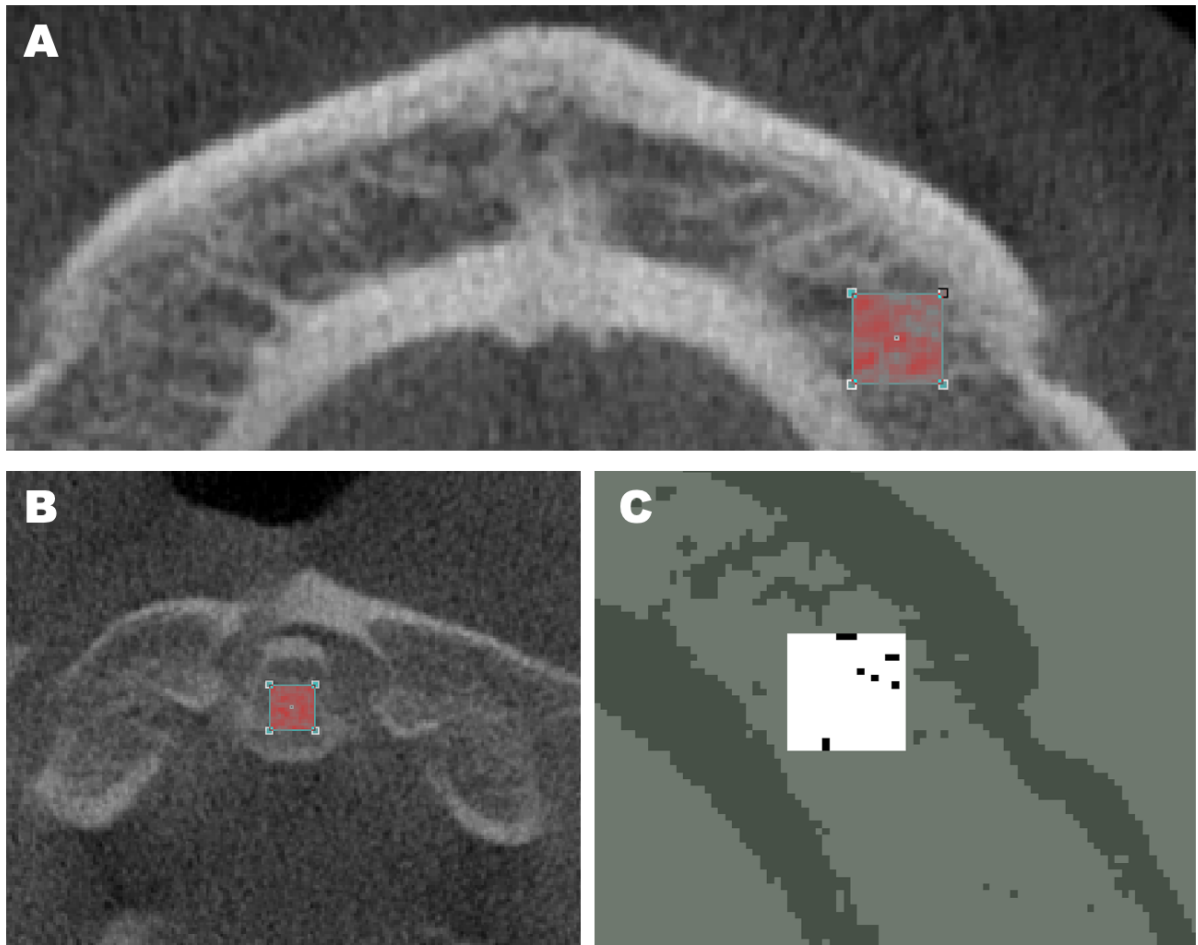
A – CBCT axial slice demonstrating the selection of the volume of interest 2 (5x5x5mm) on CTAn software located anteriorly to the mental foramen. B – CBCT slice demonstrating the selection of the VOI 1 (5x5x5mm) on the second cervical vertebra region C - Binary image created by CT Analyzer before analyzing the tridimensional parameters
